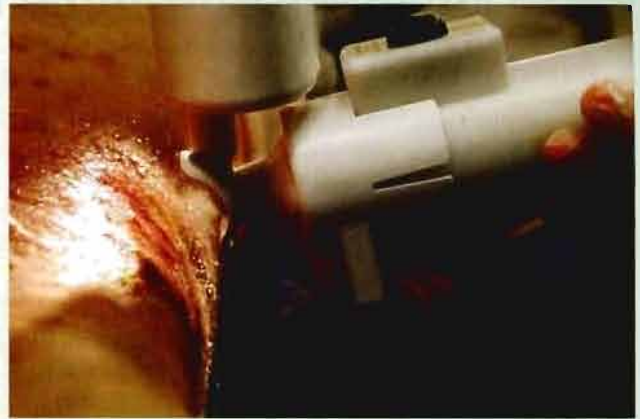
Application of noncontact low-frequency ultrasound to an open wound. Ultrasonic effervescence is visible in the form of a bubbling or frothing action at the wound surface. (Courtesy of Celleration.)
